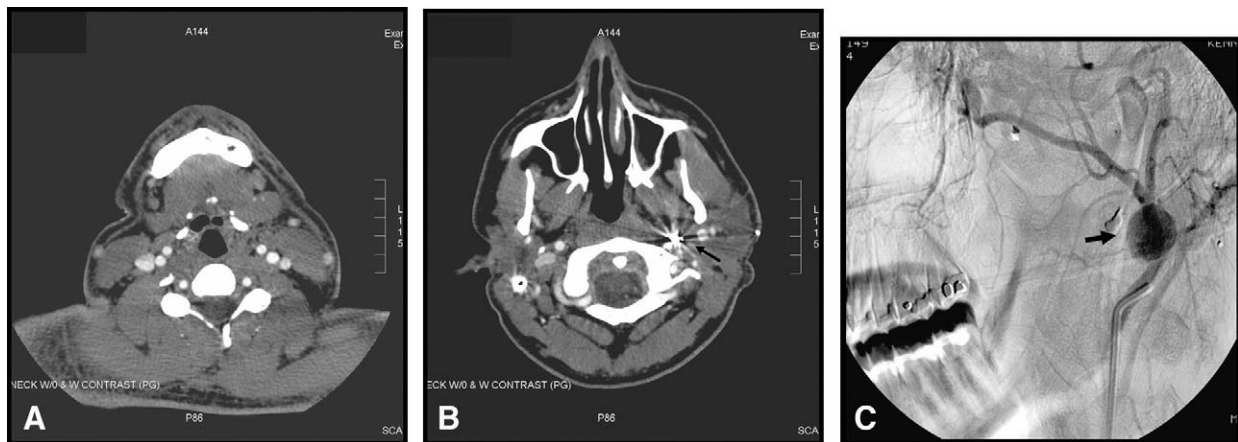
A, The quality of computed tomography angiography can be easily degraded by metallic artifact (*arrow*) (B) as depicted by subsequent sections acquired within the zone of injury. C, A carotid pseudoaneurysm (*arrow*) was later discovered on the arteriogram.
